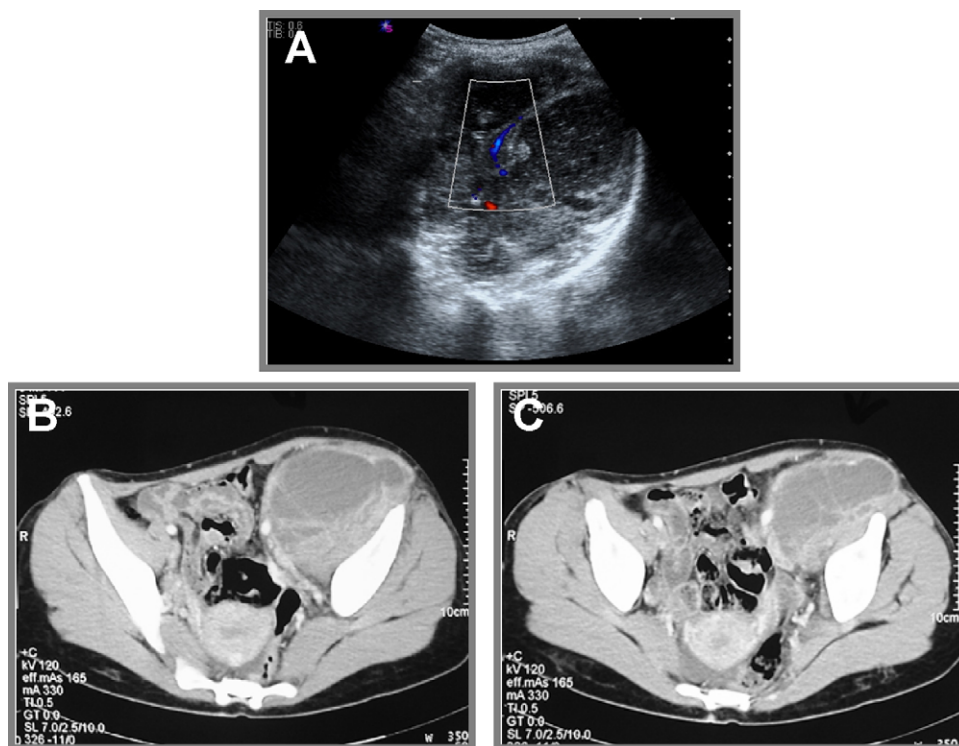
(A) Doppler US revealed dense cystic components and pathological vascularization at solid components. (B) CT examination demonstrates contrast enhancement at the solid components of the lesion. The left external iliac artery and vein are located at the lesion's wall. Free fluid is present at rectovaginal recess. (C) CT examination demonstrates a thin layer of fat between the lesion and the left ovary.
